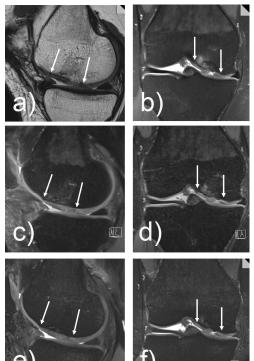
The cartilage repair tissue (arrows) in a patient after MACT depicted by standard MR sequences (a,b), an isotropic 3D-PD-SPACE sequence (c,d) and an Procisatropic 3D-True-FISP sequence (e.f. Changes within the subchondral bone are better visualized in standard MRI (a,b) and the PD-SPACE sequence (c,d).
